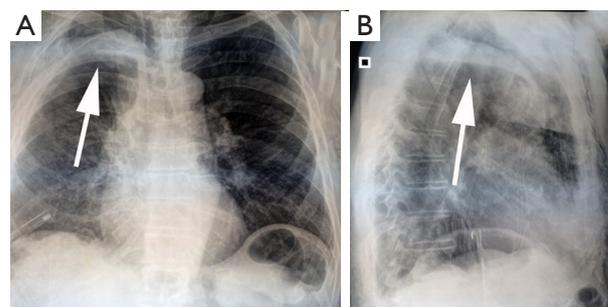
Postero-anterior (A) and lateral view (B) of postoperative chest radiograph showed the fully expanded right lung with normal vascular markings. TachoSil® (arrow) was well evident in both views.
